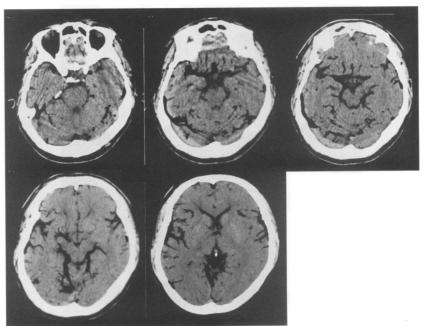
Cranial computed tomograms of a cerebral venous air embolism. Extensive and irregular low-density areas can be seen on the surface of the cerebrum.
